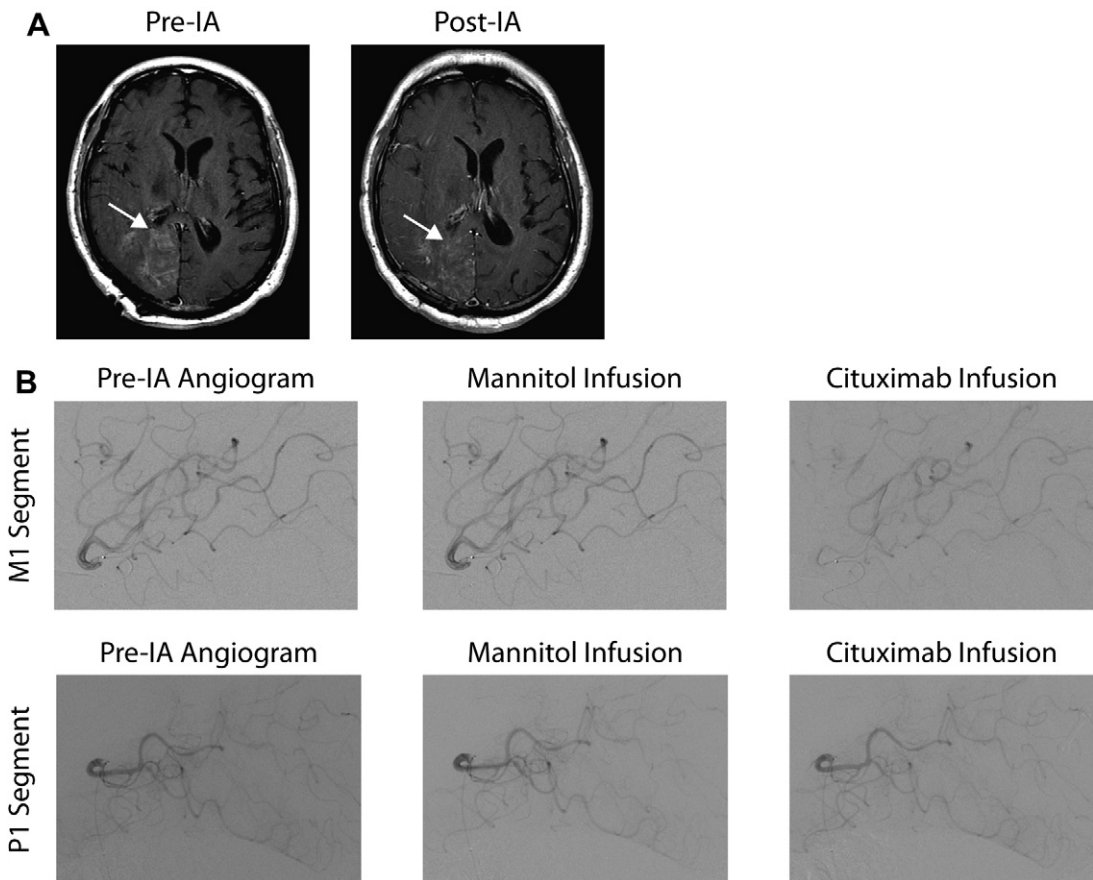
(A) T1 axial MRI with contrast before and 1 month after IA cetuximab with BBBB treatment. There is a decrease in the size and enhancement of the right periventricular parietal lesion (*arrow*) from pre-IA to post-IA treatment. (B) Fluoroscopic imaging of the pre-IA angiogram, mannitol infusion, and cetuximab infusion. The right P1 and M1 segments of the right posterior cerebral artery and middle cerebral artery, respectively, were selectively catheterized for infusion of mannitol and cetuximab to treat the right periventricular parietal lesion.
